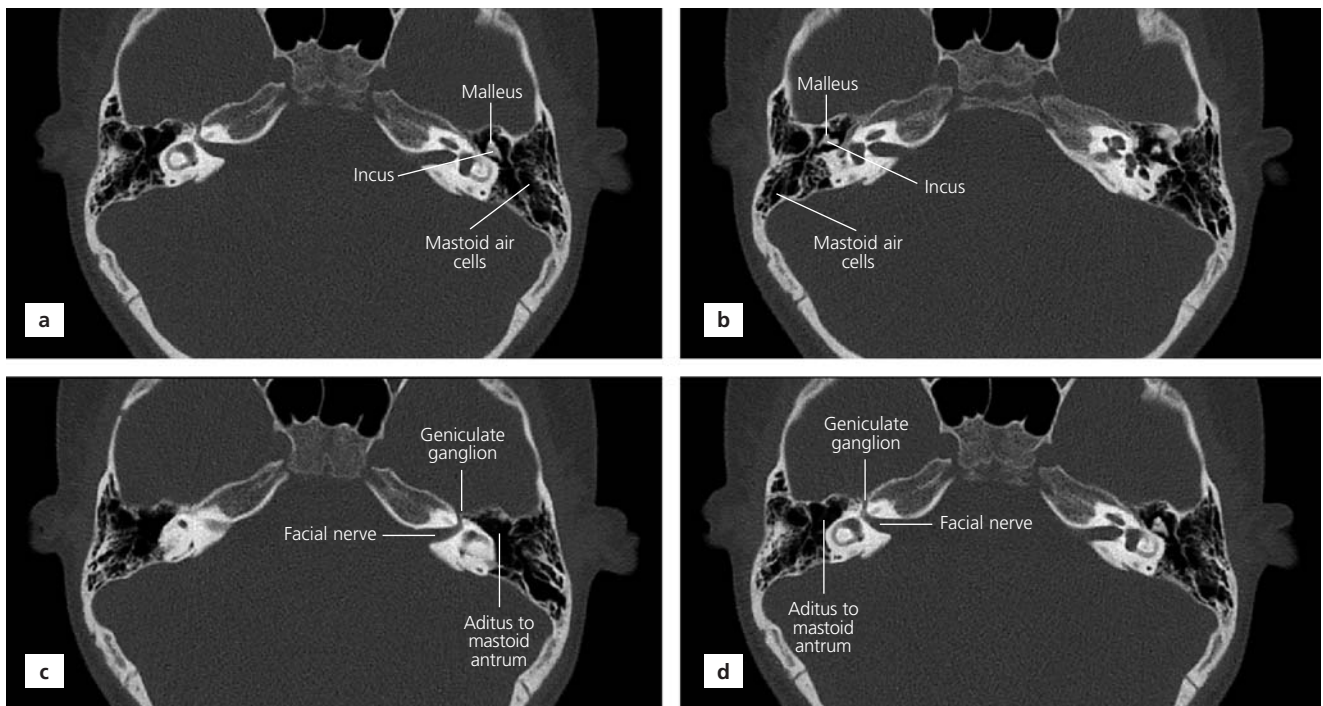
Axial thin-section CT scans (a–d). (a) Mastoid pneumatization and auditory ossicles are normal on the left side; (b) mastoid pneumatization and auditory ossicles are normal on the right side; (c) presence of aditus to mastoid antrum and facial nerve (labyrinthine segment) on the left side; (d) presence of aditus to mastoid antrum and facial nerve (labyrinthine segment) on the right side.
